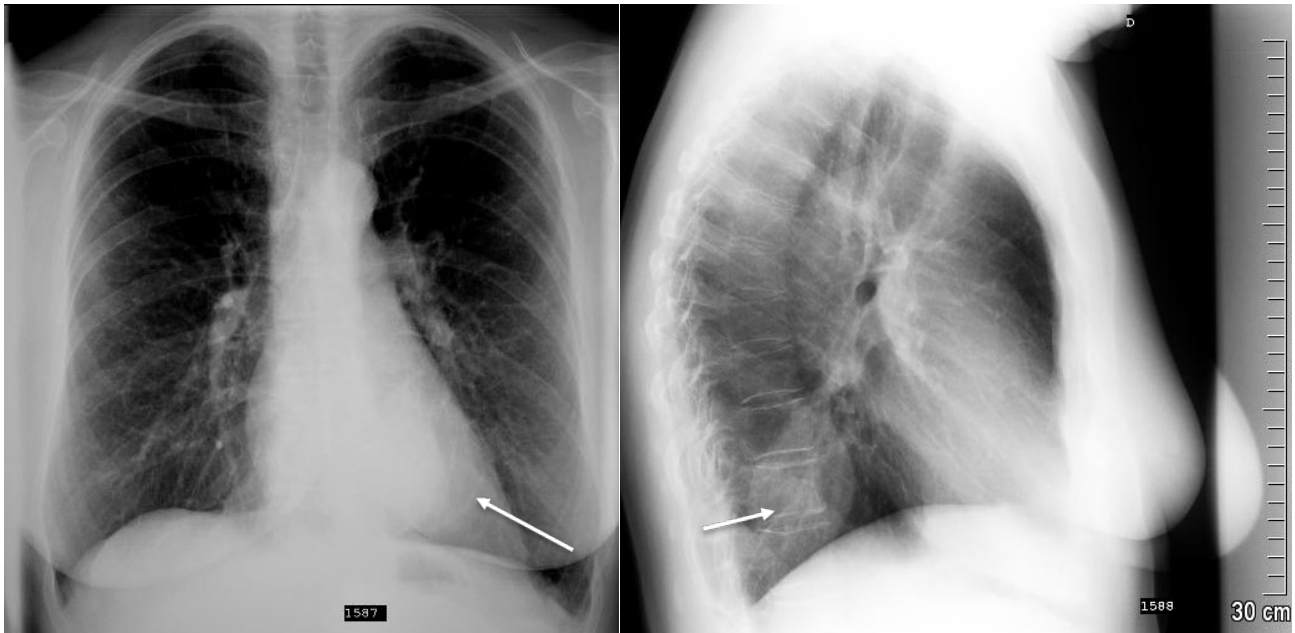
29-year patient's chest PA (a) and lateral (b) x-rays demonstrate (arrows) left lower paravertebral ill-defined pathologic masses.
